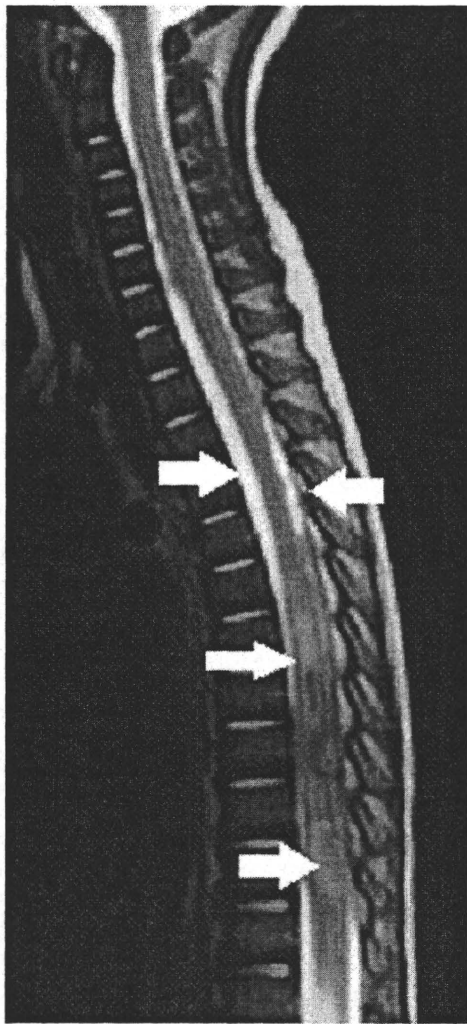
Contrast-enhanced T1-weighted magnetic resonance image obtained during the first relapse shows an extensive intraspinal pachymeningeal thickening.
